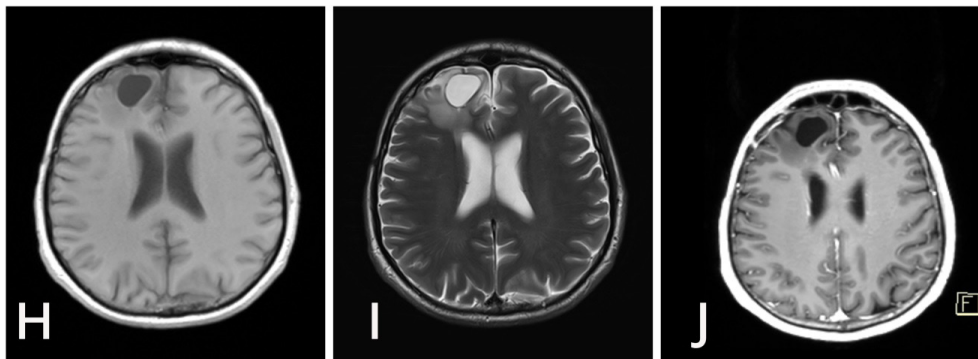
Postoperative brain MRI images on the last check-up. Axial view T1-weighted image (T1WI). (H) Axial view, T2WI. (I) Axial view, contrast-enhanced T1WI (J). Persisting non-changing cystic formation in the operative region, without any signs of tumor residue
